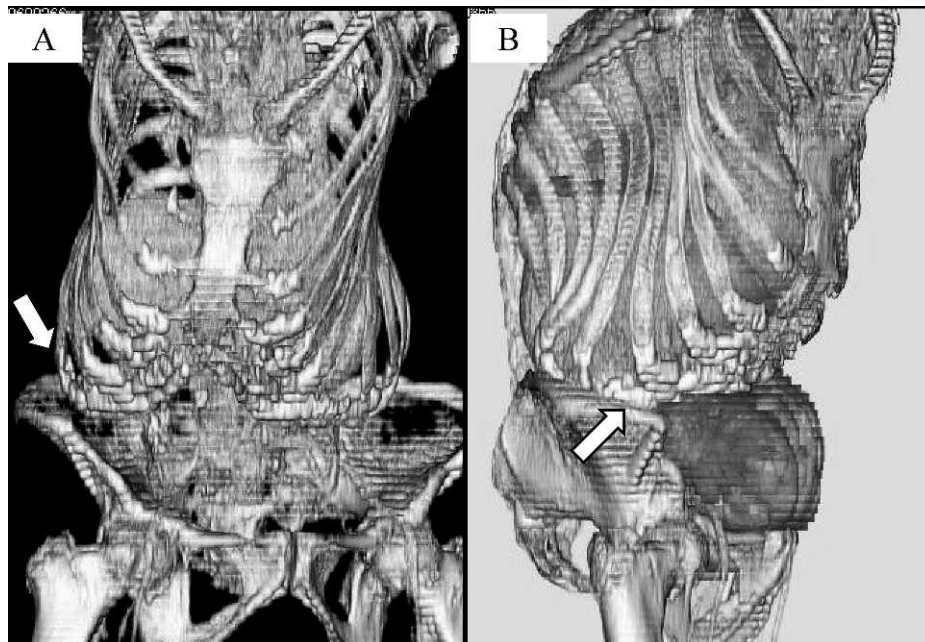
A three-dimensional reconstructed image of the abdominal CT. (A) Anterior image. (B) Lateral image. The arrow indicates intestinal compression by the costal arch.
